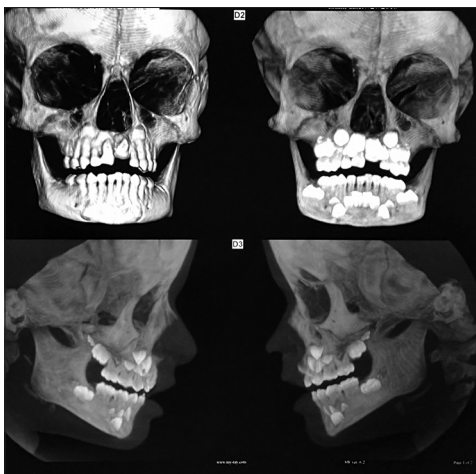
Another cone-beam computed tomography section showing impaction of 61.
